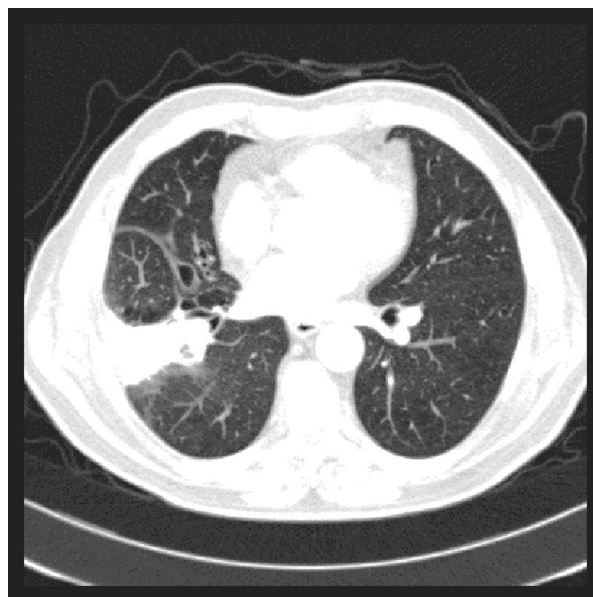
CT scans showing irregular peripheral area of consolidation with air bronchogram in the right lower lobe contacting the inferior hilum, probably enlarged lymph nodes in the region
